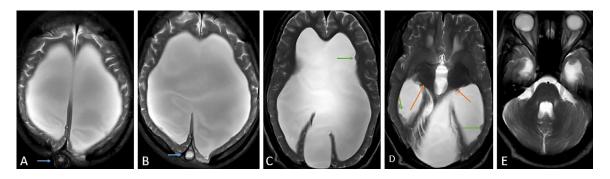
Magnetic resonance imaging of brain T2 weighted imaging sequential axial sections (A, B, C, D, and E) shows nonfusion of bilateral thalami (orange arrow). Gross hydrocephalus with nonvisualization of cavum septum and wide meningocele (blue arrows) with normal appearance of the fourth ventricle. Subependymal nodule (green arrow).
